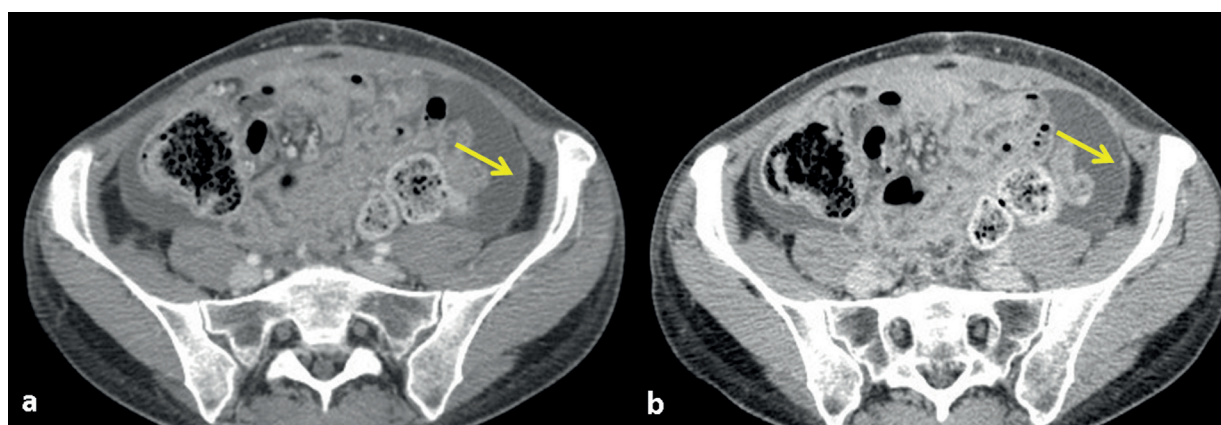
a-b, Axial CT images obtained in portal (a) and delayed (b) phases. Linear thickening of parietal peritoneum was correctly detected by less-experienced reader only at reading session C, based on the evaluation of both portal and delayed phase images (arrow in a and b), as confirmed by SOR (linear thickening of parietal peritoneum diffusely involving the left paracolic gutter). False negative case for SET A and B – True positive case for SET C.
